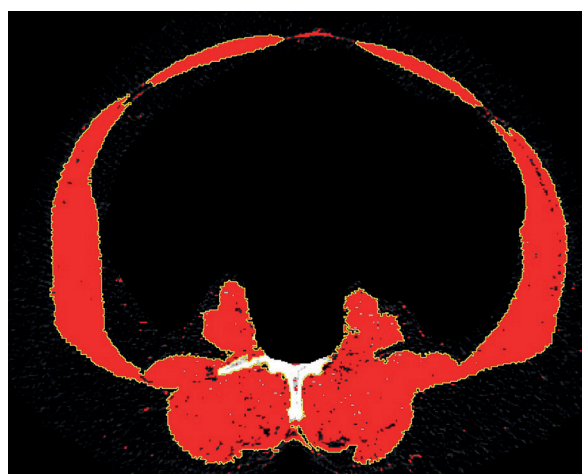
Total muscle area and muscle attenuation value measurement at the L3 vertebra corpus level on axial CT image.
